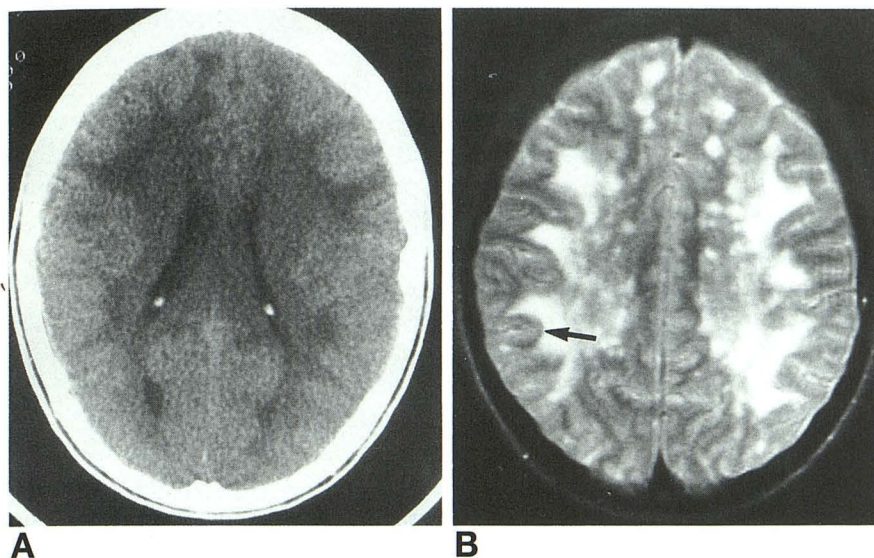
Case 1. A, Axial CT scan. B, Axial T2-weighted MR image (2100/80/2 [repetition time/echo time/excitations]). Preferential involvement of the deep arcuate fibers is indicated by the arrow.
